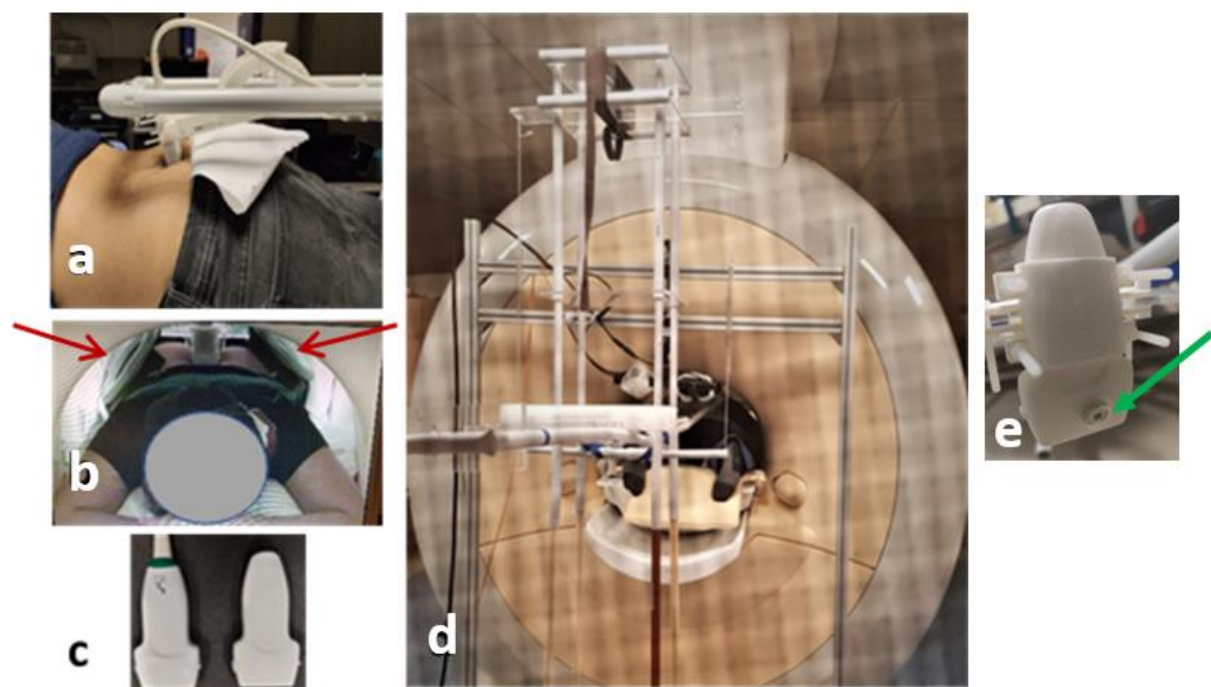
a) Ultrasound acquisition with the a SL10-2 linear probe transducer acting as an indenter. b) Participant lying in the MR scanner with two surface body coils (red arrows) placed on either side of the pelvis; c) Real US probe (left) and associated 3D-printed replica (right); d) Rear side of the MR scanner showing the rest of the setup and the participant lying in the scanner; e) Green arrow showing the cylindrical reflective marker attached to the 3D-printed indenter.
